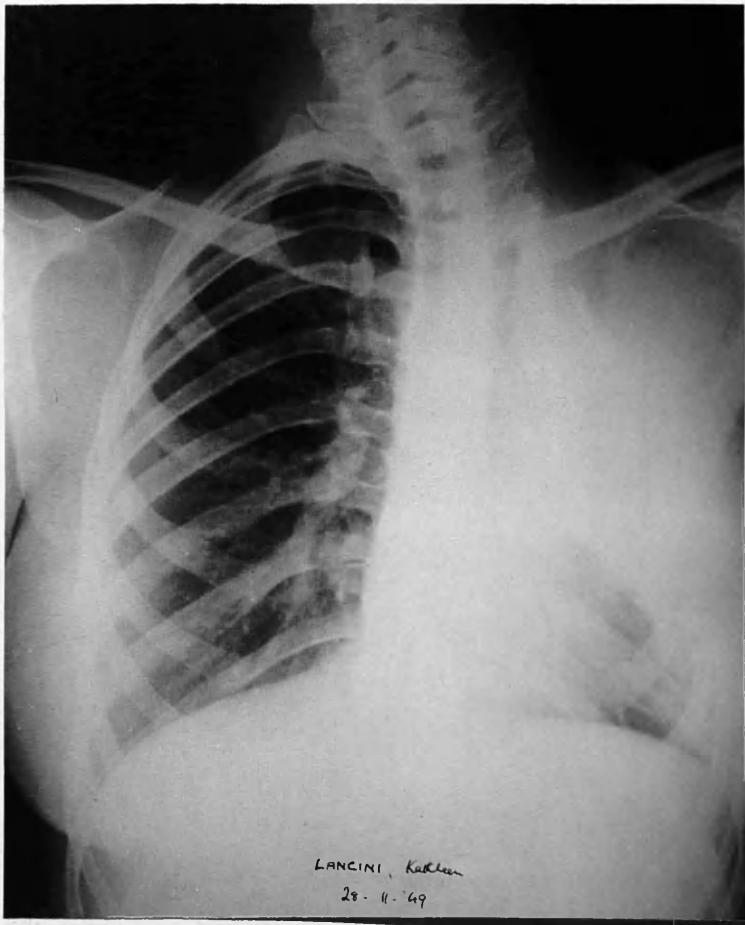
Radiograph of chest taken on 28.11.49., eleven months after a two-stage thoracoplasty had been performed for persistant cavitated disease in the left upper lobe. There is a small, hazy "smudge" shadow in the first right intercostal space.
